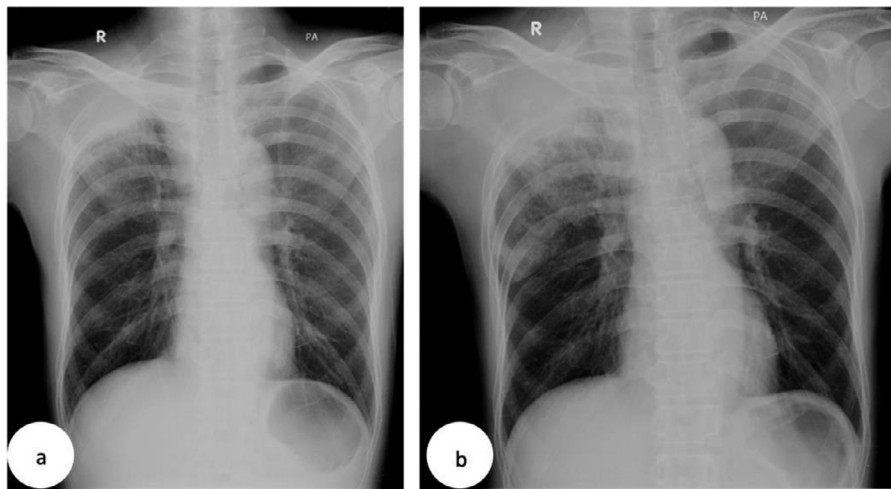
Chest x-ray images after TB medication show indeterminate border opacity in the upper lobe of the left lung, with the destruction of the second and third right ribs.
